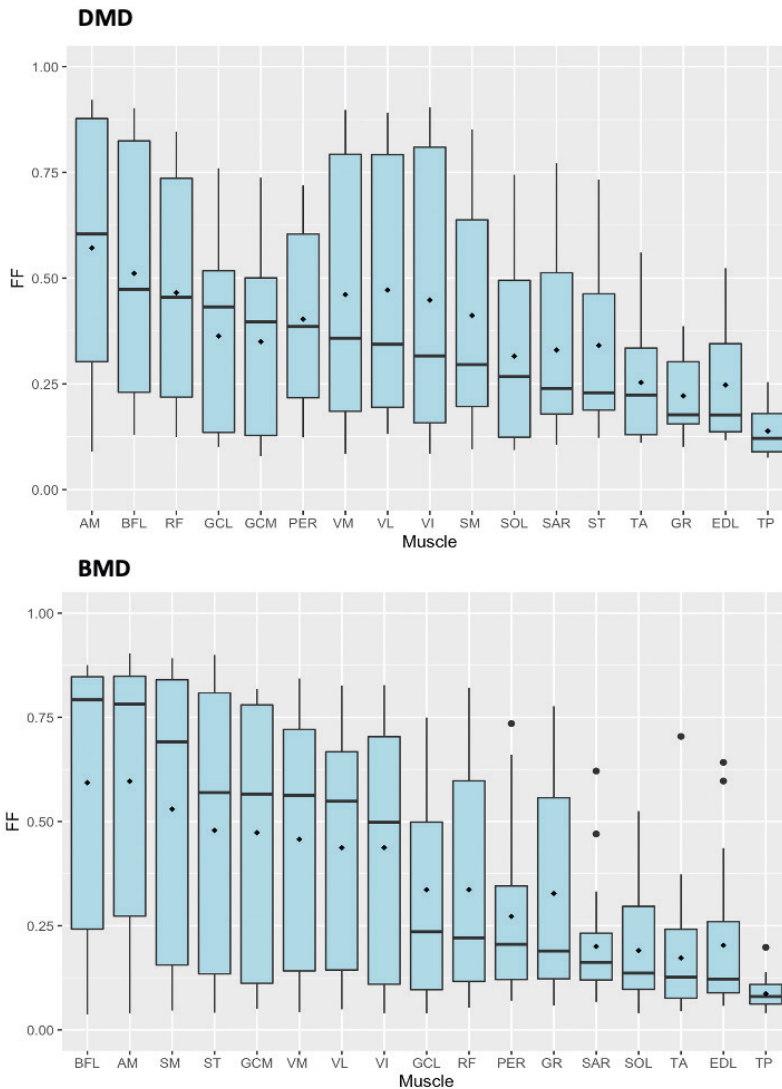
FF per muscle over all DMD (upper panel) and BMD (lower panel) patients for the baseline measurement. Lines within boxes indicate the median value and define the order on the x axis, black diamonds represent the mean, and the lower and upper bounds indicate the first and third quartiles. Upper whiskers show the largest value with, as maximum, $1.5 \times$ IQR, and lower whiskers show the smallest value with, as minimum, $1.5 \times$ IQR. Individual round dots represent outliers. Muscles are ordered from highest median FF on the left to lowest median FF on the right. Abbreviations: AM, adductor magnus; BFL, biceps femoris long head; BMD, Becker muscular dystrophy; DMD, Duchenne muscular dystrophy; EDL, extensor digitorum longus; FF, fat fraction; GL, gastrocnemius lateralis; GM, gastrocnemius medialis; GR, gracilis; IQR, interquartile range; MRI, magnetic resonance imaging; PER, peroneus; RF, rectus femoris; SAR, sartorius; ST, semitendinosus; SM, semimembranosus; SOL, soleus; TA, tibialis anterior; TP, tibialis posterior; VI, vastus intermedius; VL, vastus lateralis; VM, vastus medialis
